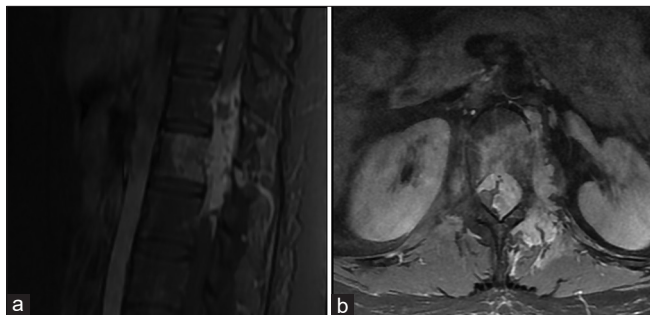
Spinal magnetic resonance imaging (a and b) showing metastases at L1 level.
